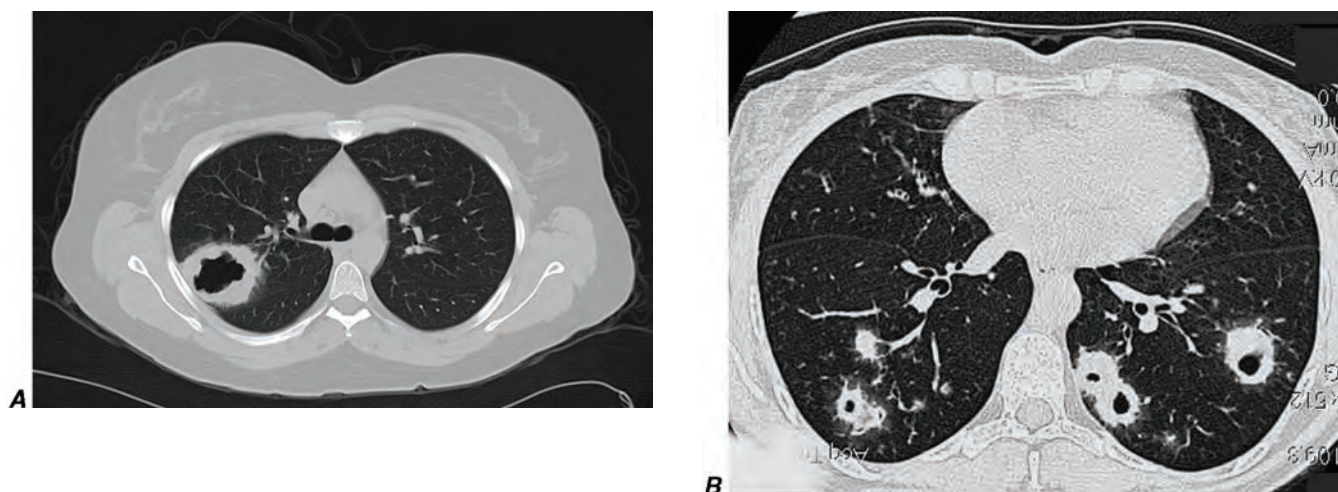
Figure e40-2 Computed tomography of the chest in two patients with granulomatosis with polyangiitis (Wegener's) demonstrating (A) single and (B) multiple cavitary lung lesions.
